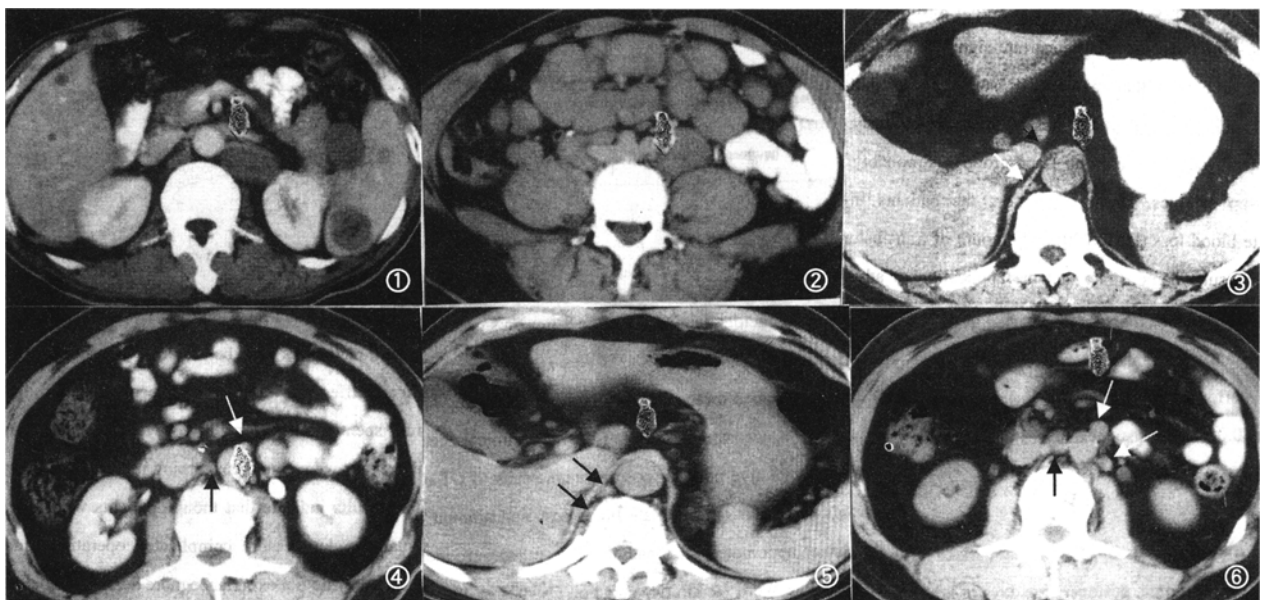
Aggressive NHL (mantle zone lymphoma). Previously untreated patients. Enhanced CT scan showed solitary lymph adenopathy in splenic hilum and retroperitoneum with homogeneous density, which is similar to that of muscle. CT value after enhancement increased by 20~31HU. Liver and spleen were simultaneously involved.
